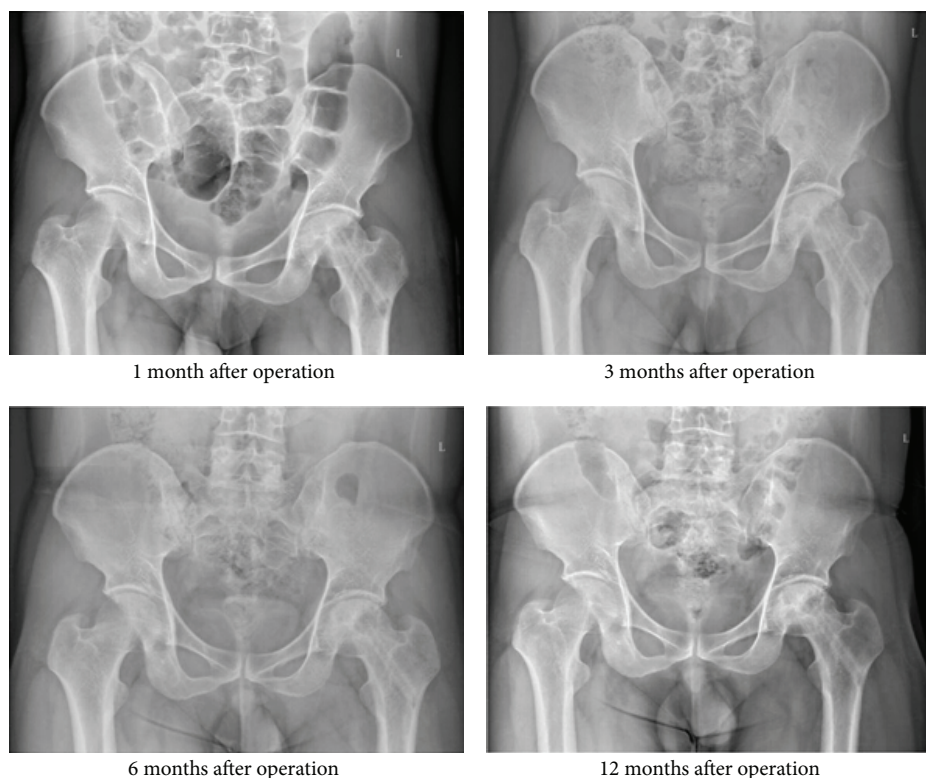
X-ray picture of normal position of pelvis at the 1th, 3rd, 6th, and 12th month after surgery.
